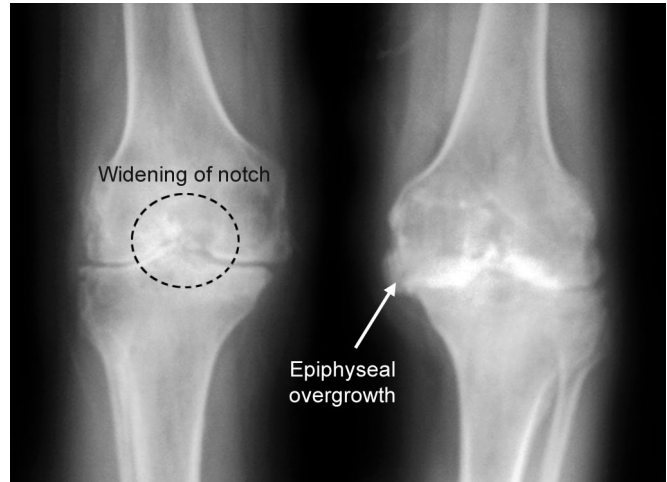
Anteroposterior X-ray view of both knees showing signs of hemophilic arthropathy.
